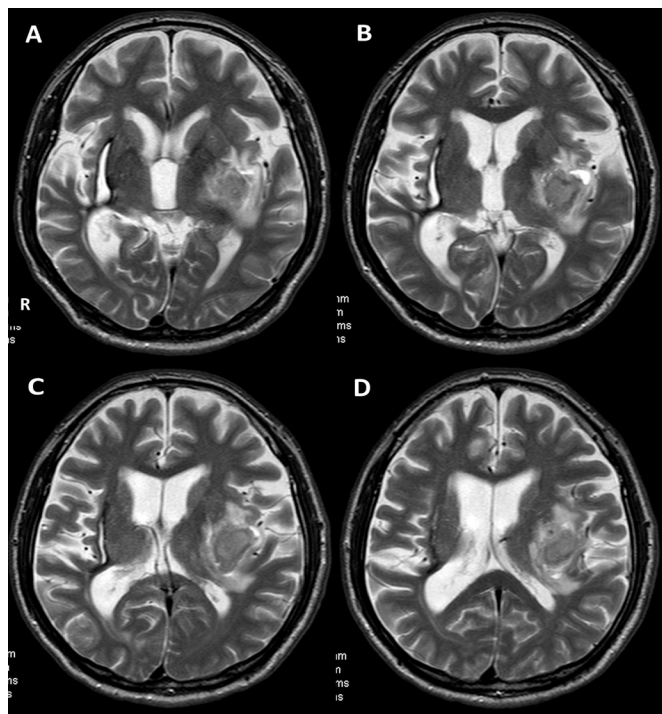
Brain MRI on day 9. There was subacute haemorrhage in the left putamen on T2-weighted image (A–D). The size of lesion was not so different from the CT image on admission. The mild surrounding oedema remained.
